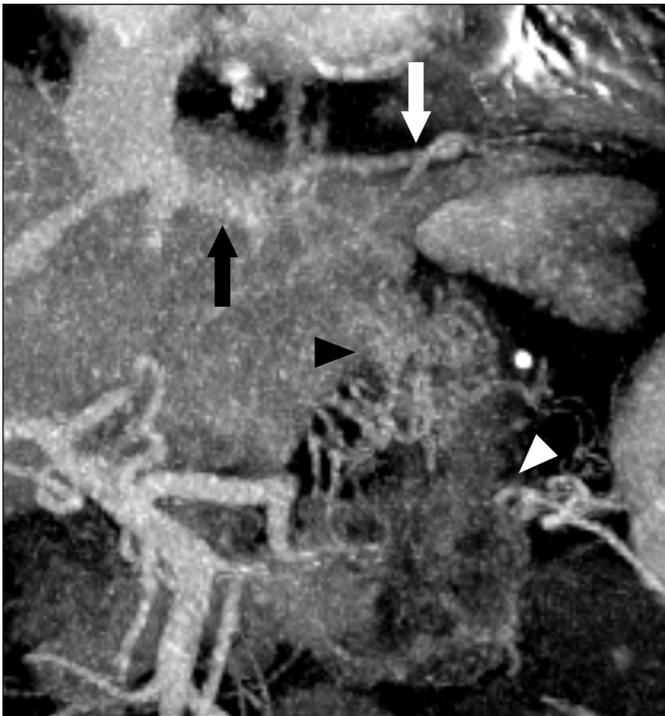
Abdominal CT showing gastric varices (black arrowhead) due to the splenic vein occlusion by pancreatic tail cancer (white arrowhead) and the gastrocaval shunt that drains via the left inferior phrenic vein (white arrow) into the left hepatic vein (black arrow).
